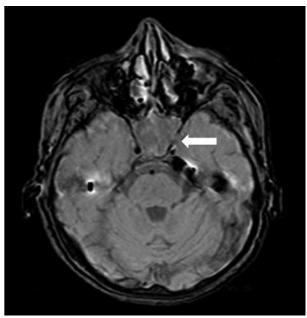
Axial FLAIR MRI shows the lysis (arrow) in the lateral wall of the left sphenoid sinus.
